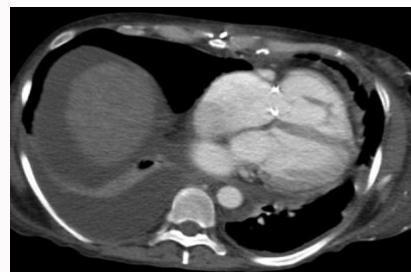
Contrast enhanced CT of the chest 3 months after therapy demonstrates complete resolution of the pericardial effusion.
